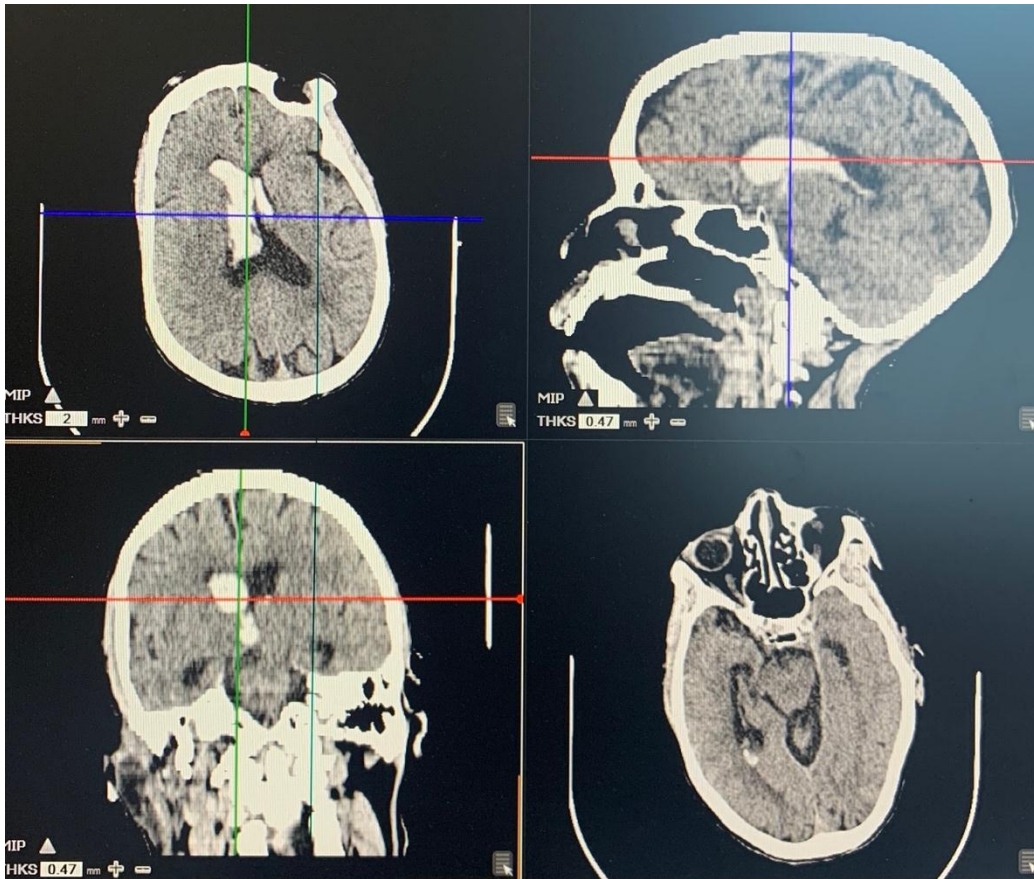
Multiplanar non-enhanced Brain CT of a 76-year-old male in axial, sagittal and coronal planes. The images demonstrate a hyperdense lesion in the right caudate nucleus with intraventricular extension of the ipsilateral lateral ventricle and the third ventricle.
